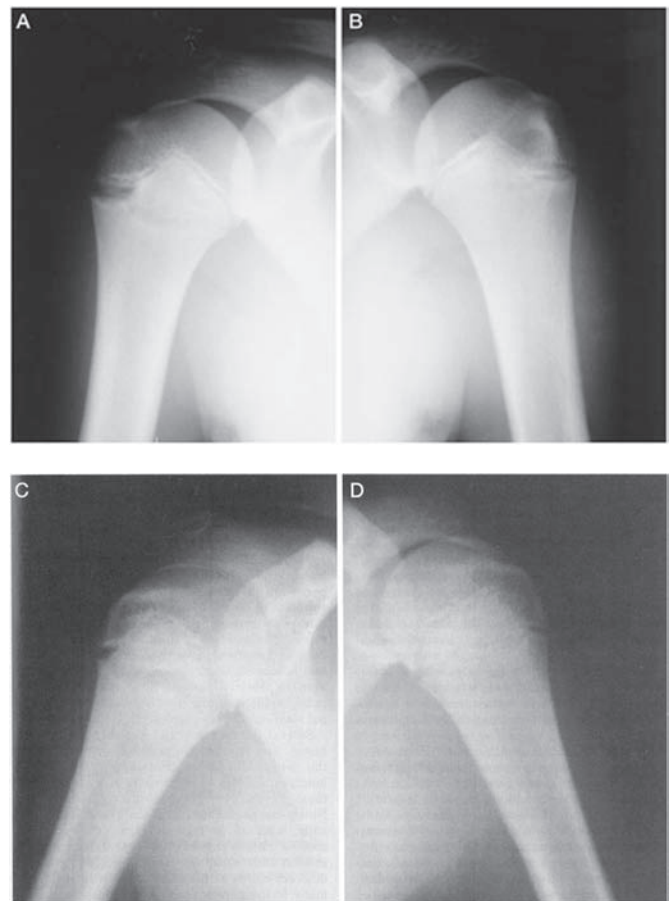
Radiographs of skeletally immature patients. (A and C) Physeal widening commonly seen in Little League Shoulder in internal and external rotation, respectively. (B and D) A reference for a normal appearing physis in a skeletally immature patient in internal and external rotation, respectively. Reproduced with permission from Carson *et al.*³³
